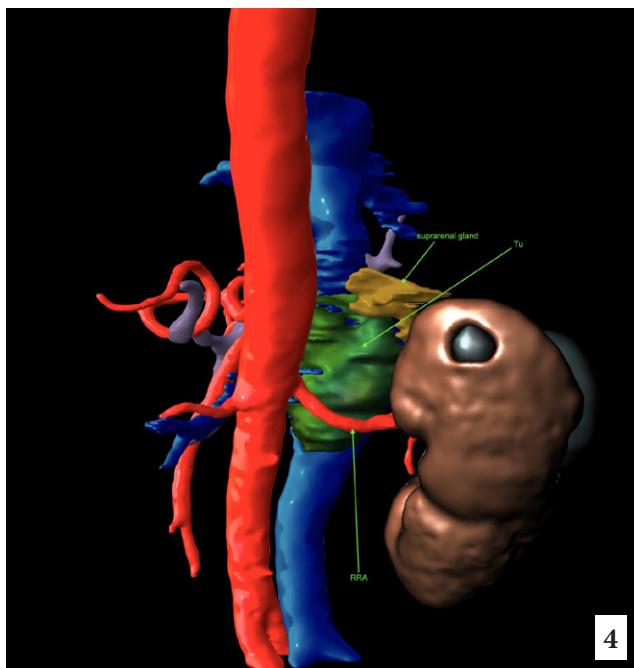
CT angiography presenting the VCI tumor (green) and surrounding structures (PV – portal vein; LRV – left renal vein; RHA – right hepatic artery; RRA – right renal artery; RRV – right renal vein; LRV – left renal vein; LHV – left hepatic vein; MHV – middle hepatic vein; RHV – right hepatic vein).
